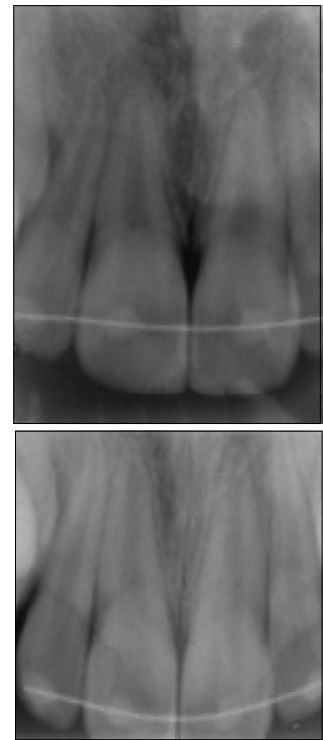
Periapical and occlusal radiographs recorded after splinting and restorations completed
